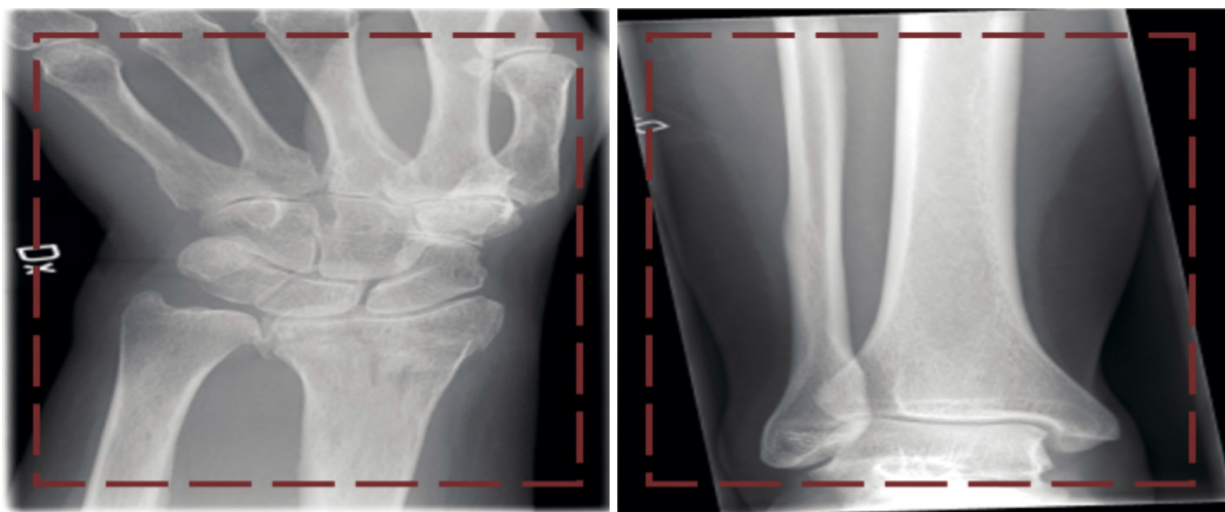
Two images (left, wrist fracture; right, no fracture) from the dataset presented to the network[74]. Reused with permission. Citation: Olczak J, Fahlberg N, Maki A, Razavian AS, Jilert A, Stark A, Sköldenberg O, Gordon M. Artificial intelligence for analyzing orthopaedic trauma radiographs. *Acta Orthop* 2017; 88: 581-586.
